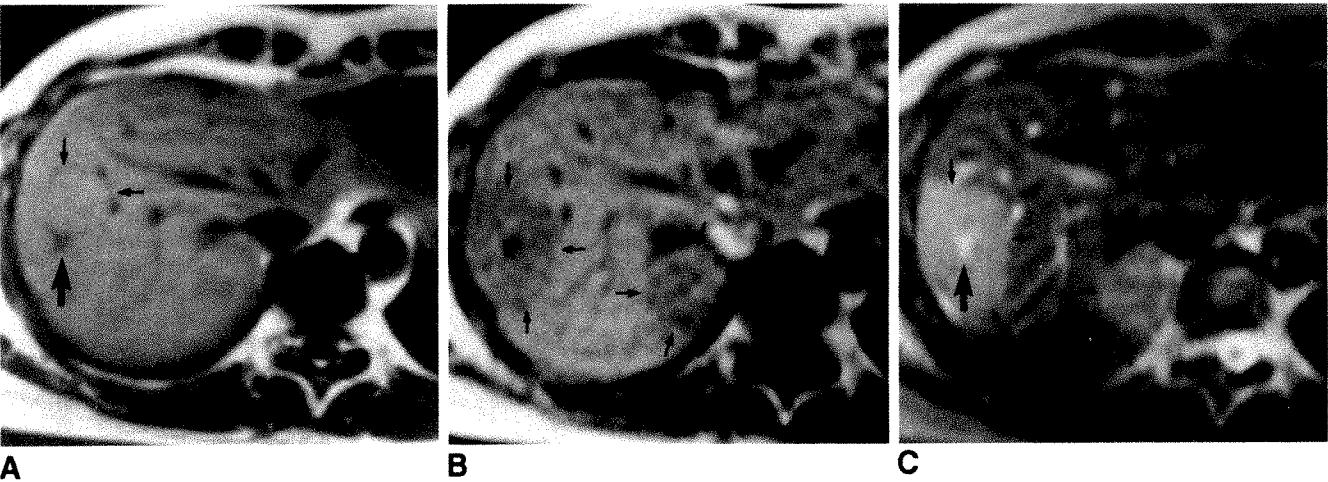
Effect of increasing T1 weighting (1.5 T) on MR imaging. Two lesions are present.
